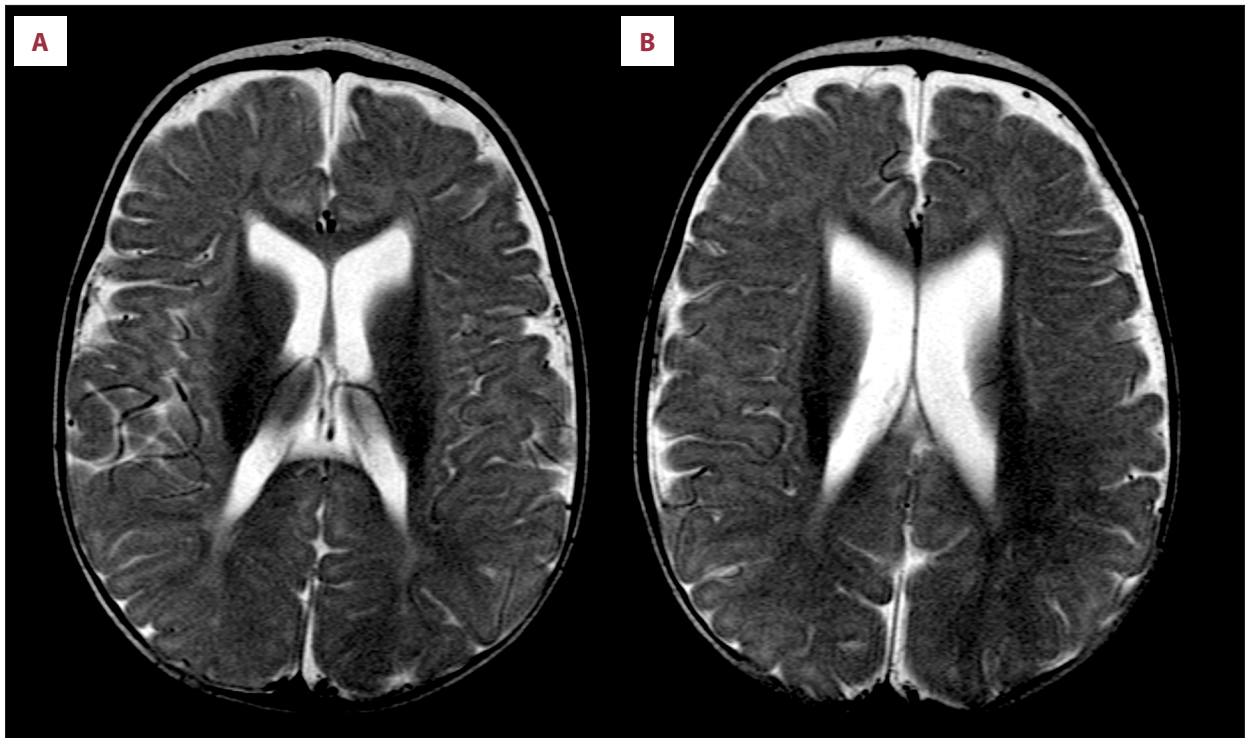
Brain MRI of the patient. At 7 months of age, axial T2-weighted images of 2 contiguous slices: (A) at the level of the lateral ventricles and basal ganglia and (B) immediately superior to that, at the level of corona radiata showed a reduced volume of periventricular white matter, with subsequently slightly *ex vacuo* enlarged lateral ventricles, especially frontal horns. Also, there was unfinished myelination, which was within the normal limits for the chronological age of 7 months at the time of scan.
